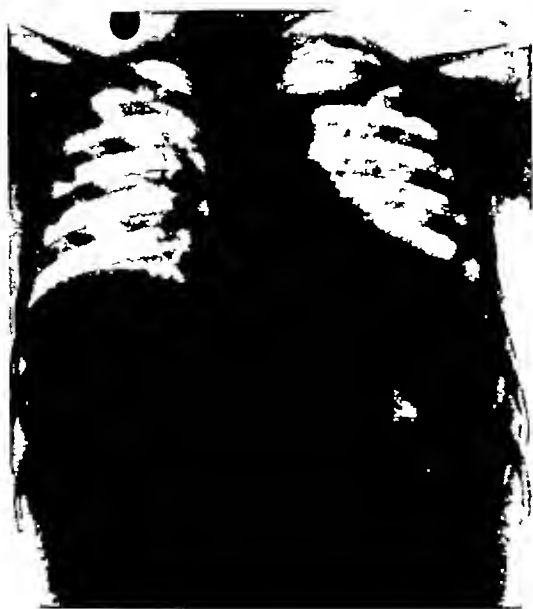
Roentgenogram of same patient in the upright position, taken on the same day. The mass which was made by the subphrenic abscess is to be seen through the gastric bubble.
